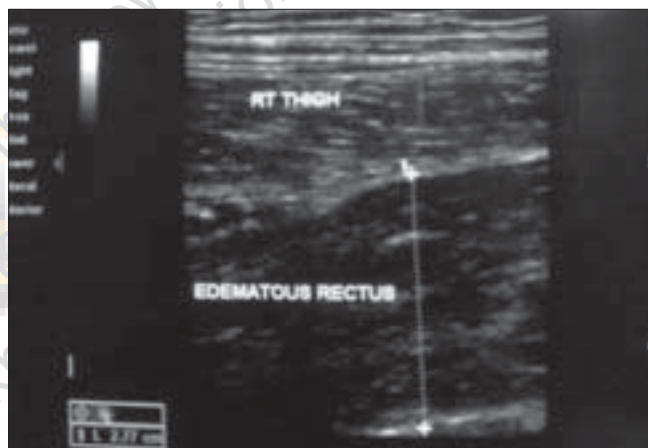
Ultrasonography of the right thigh showing thickened and edematous right rectus femoris muscle
